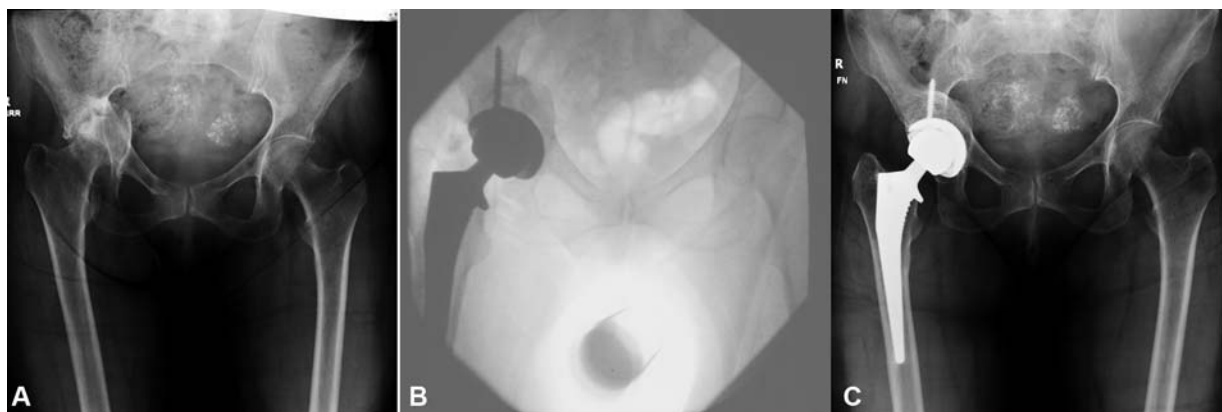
Radiographs of a 68 year old with a central fracture dislocation 1 year after injury. (A) Preoperative radiograph of the pelvis. The right hip with an unstable anterior column, posterior hemitransverse fracture with nonunion. (B) Intraoperative fluoroscopy shows adjunctive morcellized femoral head autografting. (C) Anteroposterior radiograph of the pelvis taken at 8 years of follow-up.
